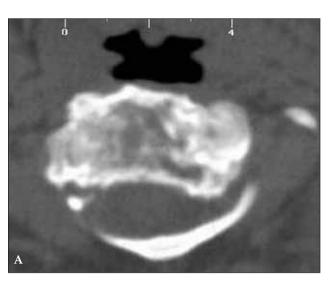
A (axial) CT 1 year after operation revealing sclerosis at the tumor site. B (sagittal) Postcontrast sagittal MRI showed no recurrence at the tumor site and no compression of the anterior subarachnoid space.
